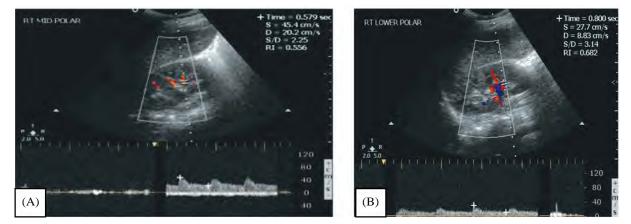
(A) Doppler wave of the right mid-polar segmental artery (B) Doppler waveform of right lower polar artery in 7 years old boy with acute glomerulonephritis.
